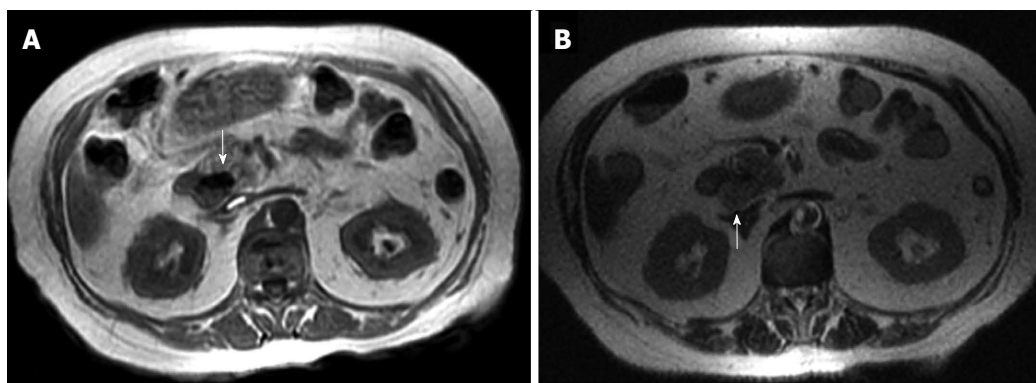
Adenocarcinoma has low signal intensity on T1 (A) and T2 (B) weighted magnetic resonance imaging (arrows).
